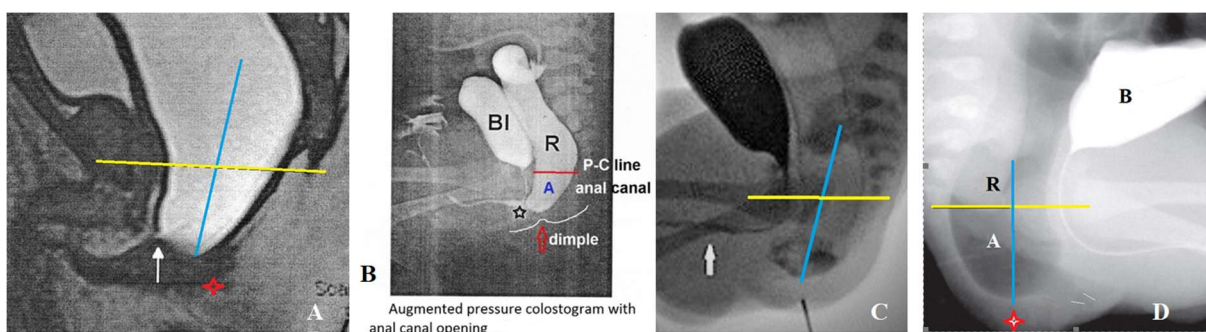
Lateral radiographs of anorectum in boys with ARM without visible fistula. (A-B) Augmented pressure colostogram in patients with urethral fistulas. (C-D) Radiographs of newborns with perineal fistula. (C) at the root of the scrotum: (D) A very narrow perineal fistula.
